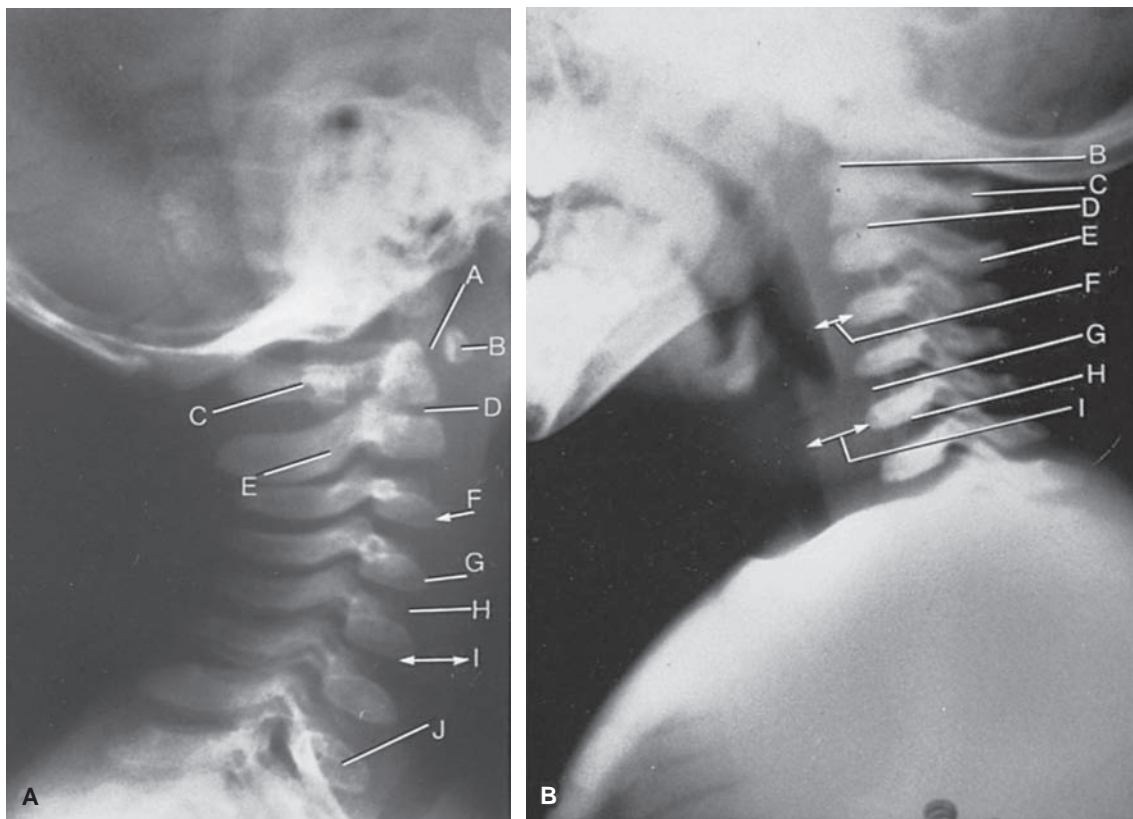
Normal pediatric lateral cervical spine radiographs. A: Three-month-old child. B: Twenty-month-old child. A, predental (predontoid) space; B, anterior ring of C1 (note apparent override of C1 over dens); C, posterior ring of C1; D, dens synchondrosis (growth plate); E, posterior elements C2; F, normal prevertebral space (C3 level); G, wedged vertebral appearance caused by cartilage artifact; H, intervertebral disc space; I, normal prevertebral space below the glottitis (thickened because of radiopaque collapsed esophagus); and J, vertebral body C7.
